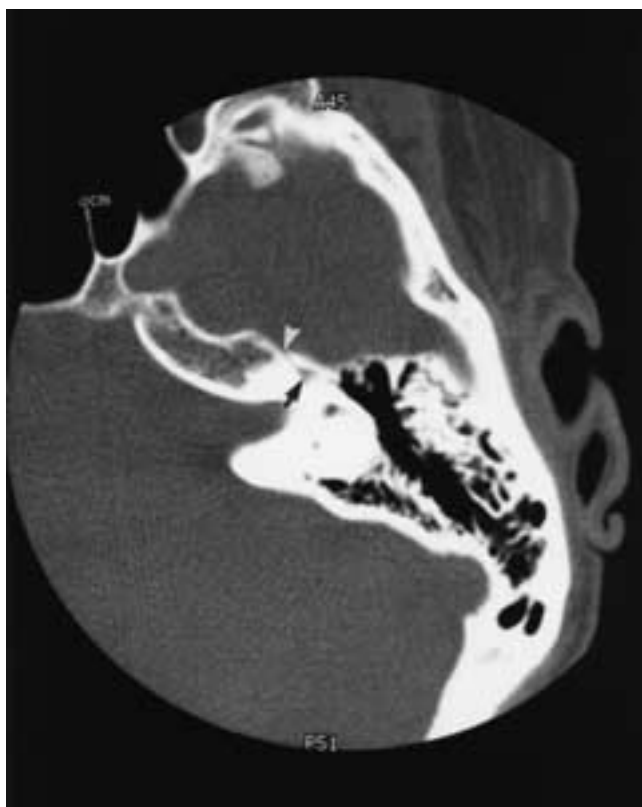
Axial CT bone window demonstrating the facial hiatus (arrowhead) for the greater superficial petrosal nerve, extending anteriorly from the geniculate ganglion (arrow). (From Ginsberg LE, DeMonte F, Gillenwater AM. Greater superficial petrosal nerve: anatomy and MR findings in perineural tumor spread. *AJNR* 1996;17:389–393.)
